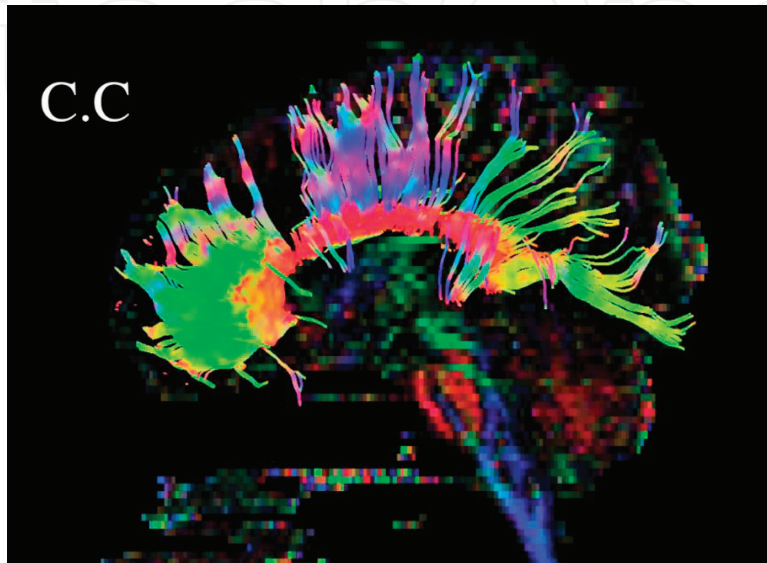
MRI tractography in sagittal view showing corpus callosum (C.C) fibers.
